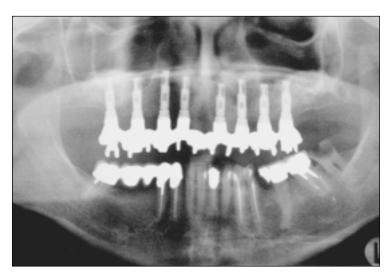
Panoramic radiograph after final prosthetic rehabilitation.
